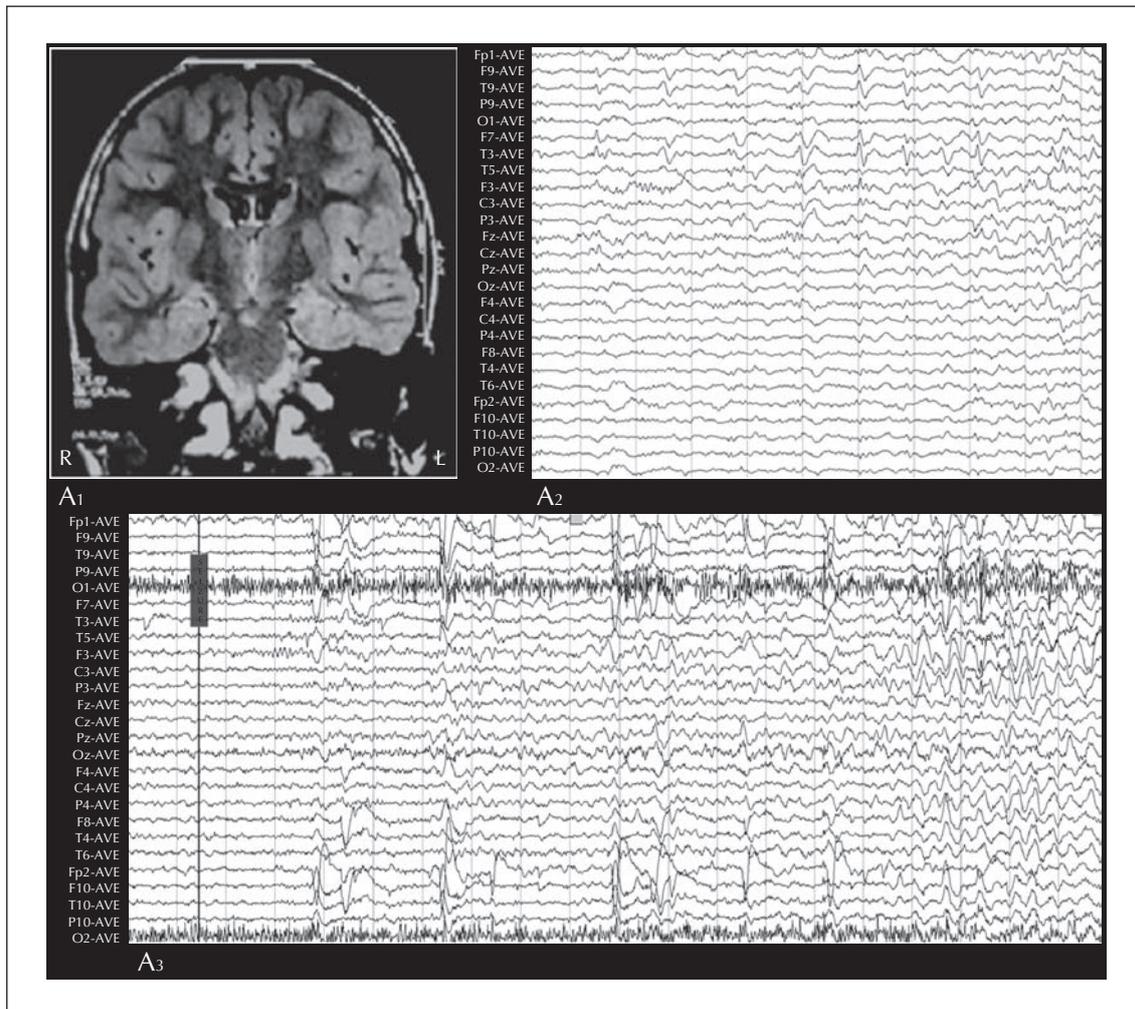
Patient 4. (A₁) MRI showing extensive left medial-basal and inferior lateral temporal FCD. (A₂) Interictal EEG shows anterior-midtemporal SWs (F7/T3/F9/T9). (A₃) Ictal EEG showing a low-amplitude fast rhythm over the left lateral frontal region (F3), subsequently spreading over the ipsilateral parasagittal region.
